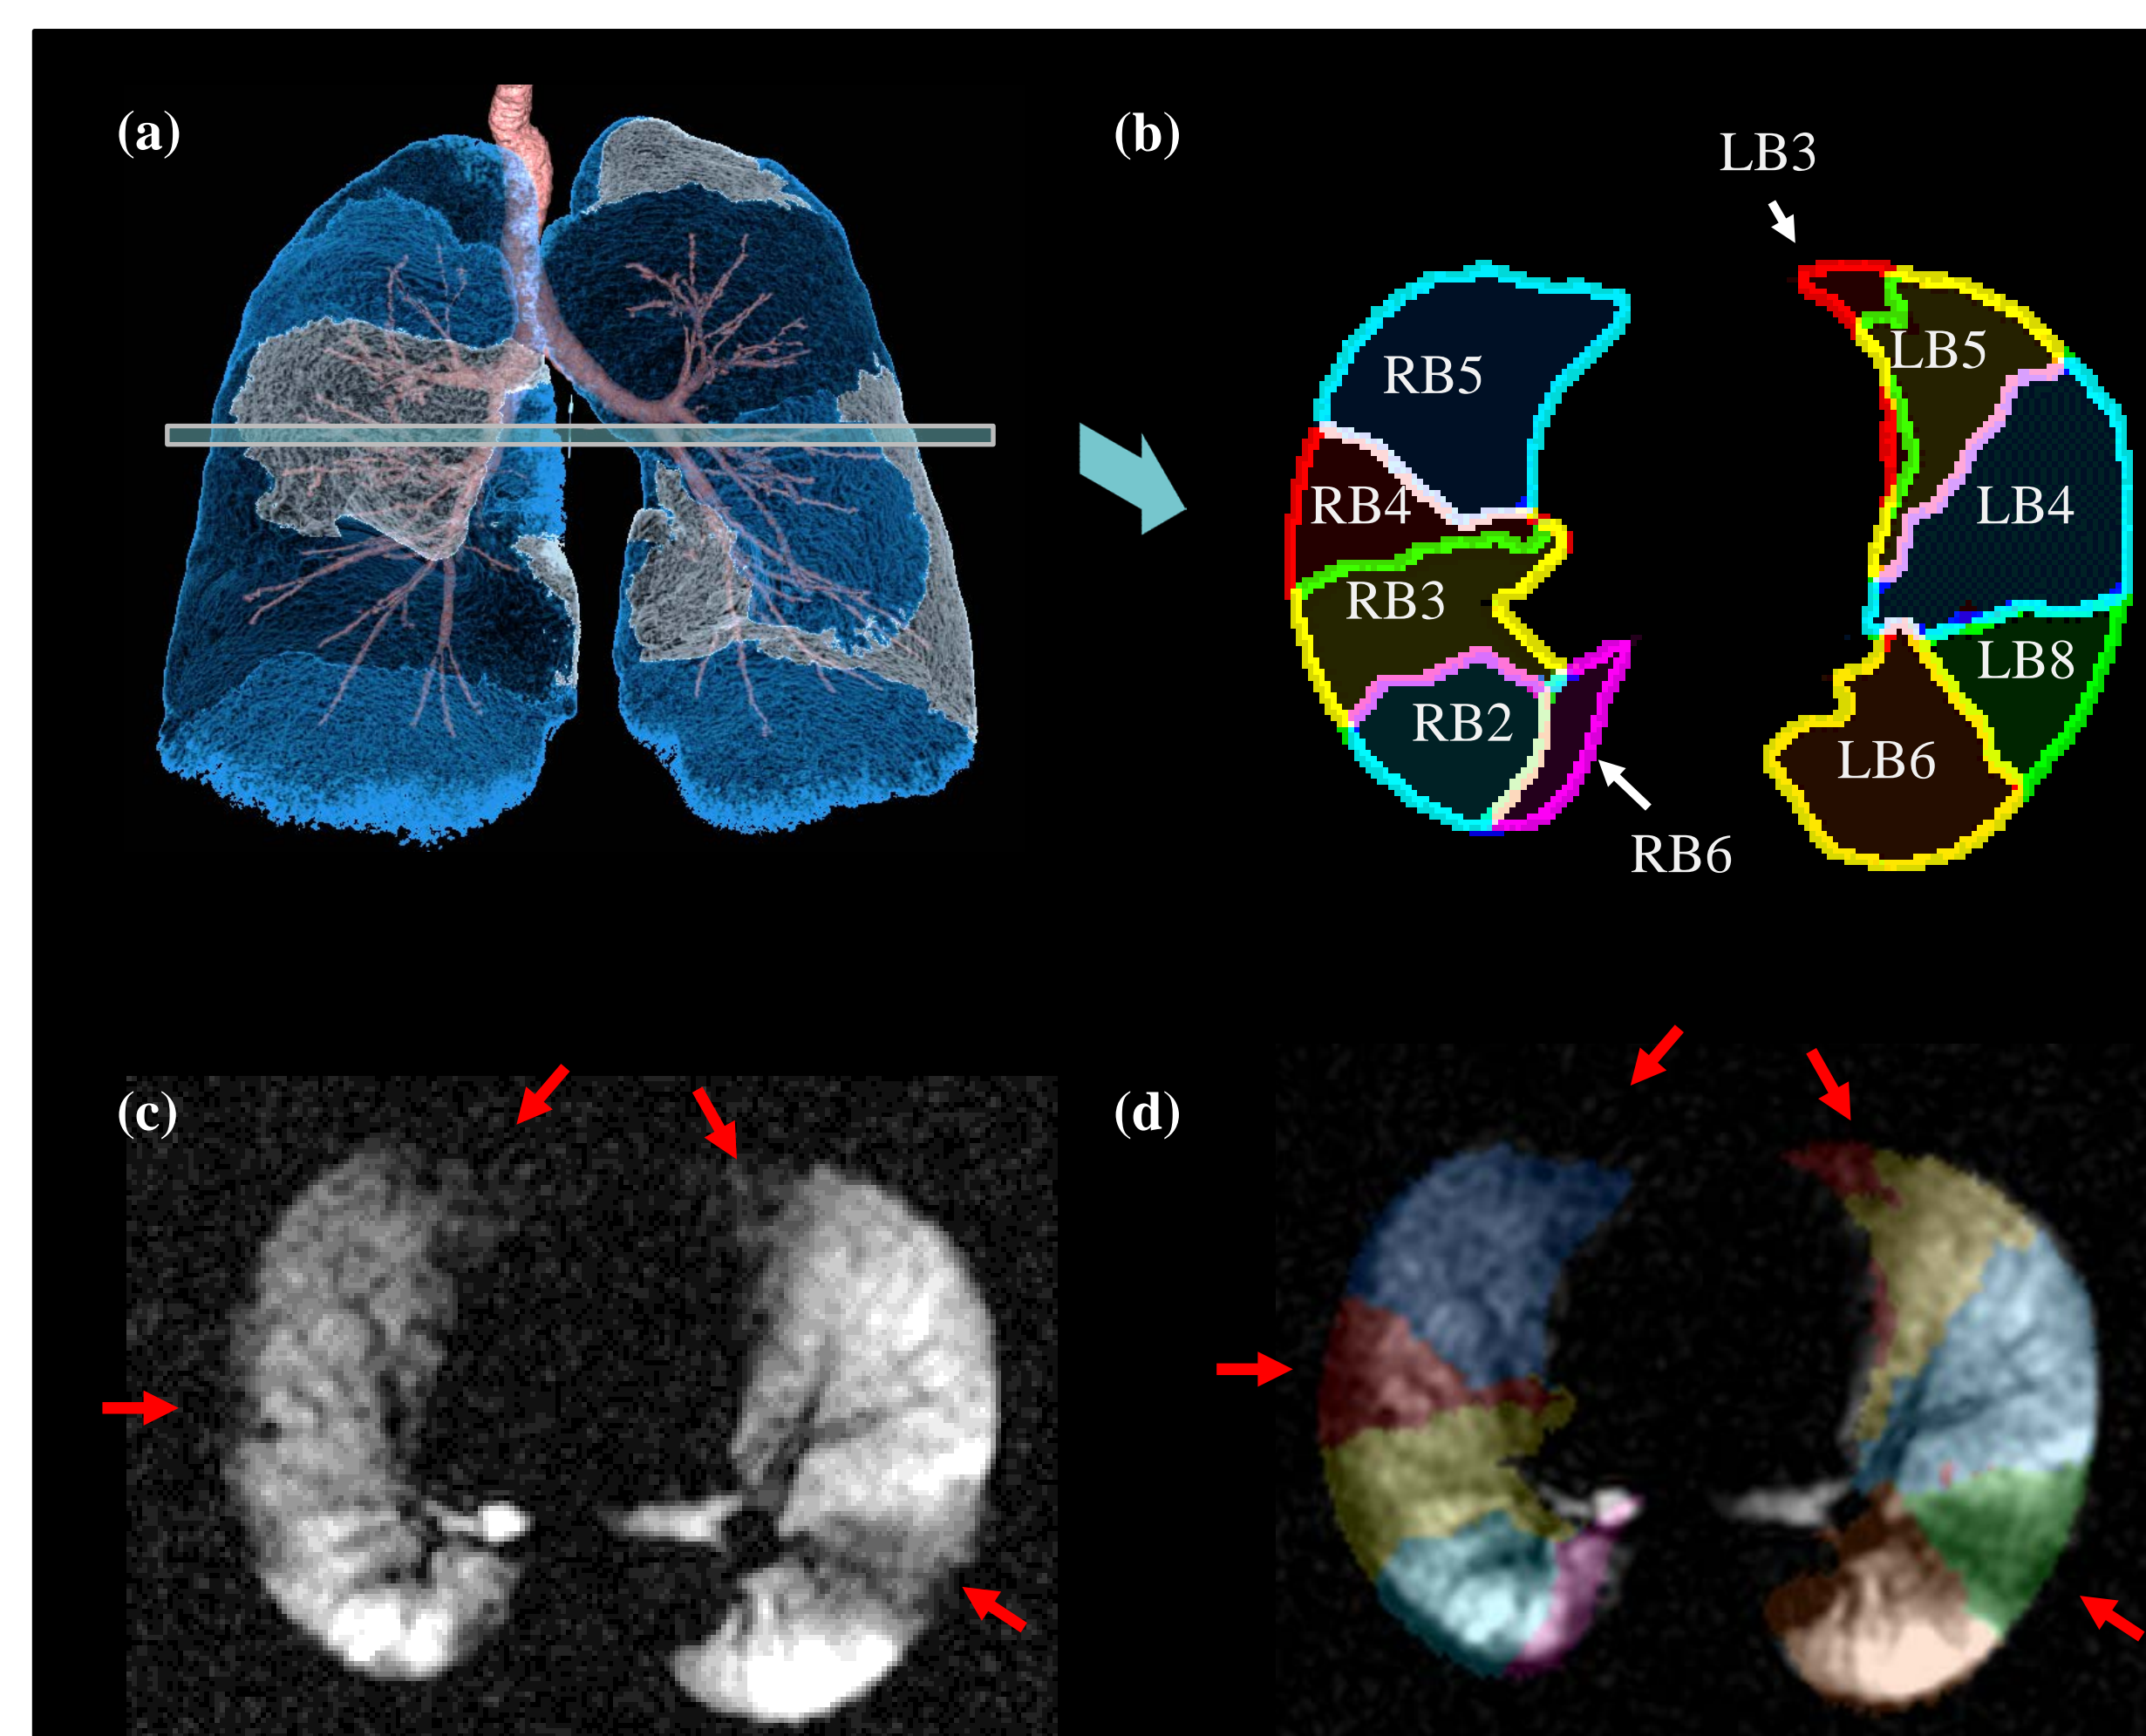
Identification of segmental volumes on CT in (a) allows for axial segment mask shown in (b) [3]. This mask can be overlaid on HP ³He MRI image (c) to identify spatial distribution of ventilation defects and calculate segmental VDP (SVDP). RB2-3 are segments of RUL, RB4-5 of RML, and RB6 of RLL; LB3-5 are segments of LUL, LB6 and LB8 of LLL. Note spatial overlap of prominent ventilation defect (red arrows) with segment LB8.
